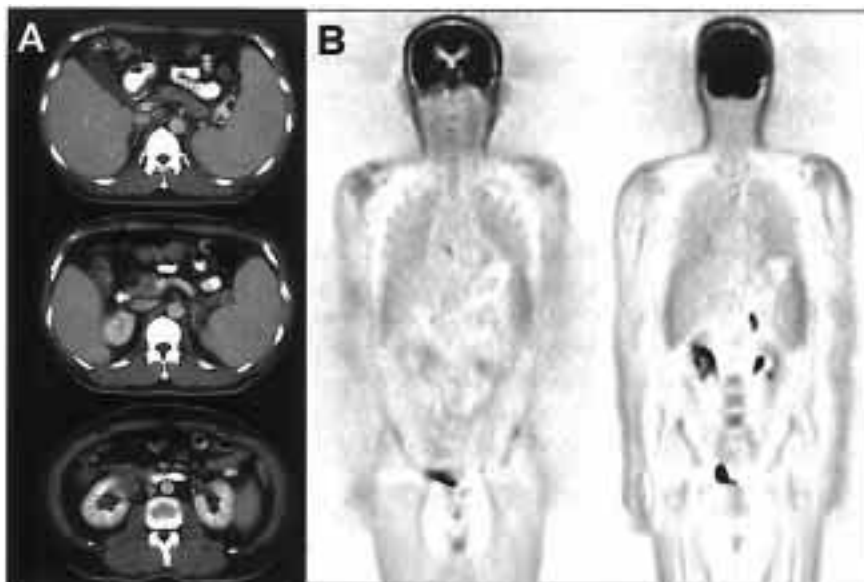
A 56-year-old male patient with extensive, intermediate-grade NHL. A: CT images demonstrate splenomegaly, a left adrenal tumor and a right renal tumor. These findings disappeared after treatment. B: FDG-PET demonstrated an abnormally high uptake only in the left adrenal gland.
